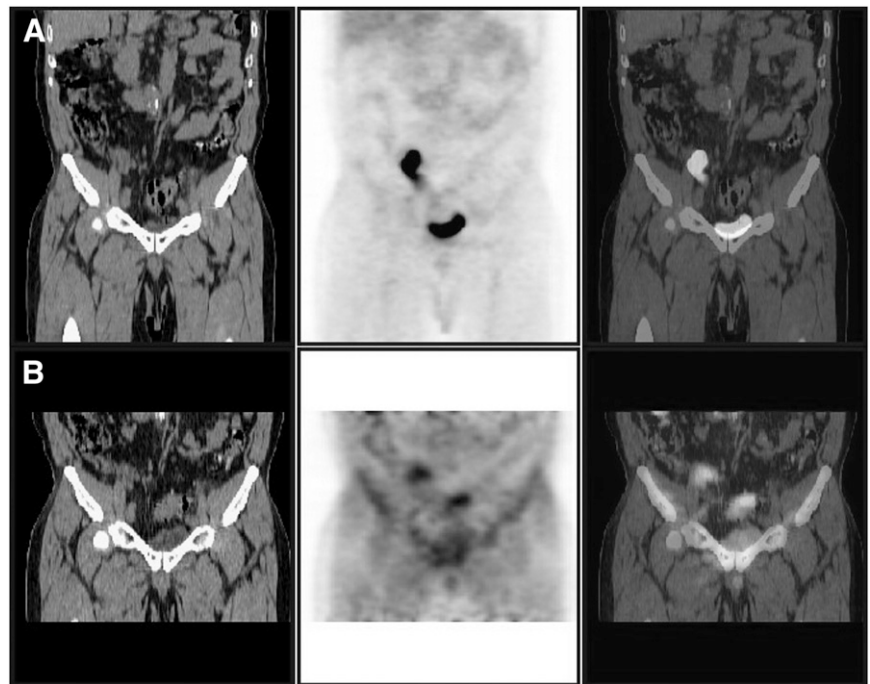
A 53-y-old male patient. CT, PET, and PET/CT images (from left to right) before furosemide (A) are normal. Delayed pelvic PET/CT images (B) after intravenous furosemide and oral hydration show hypermetabolic lesions in bladder wall and in prostate gland (arrows) that could not be identified before diuretic injection.
